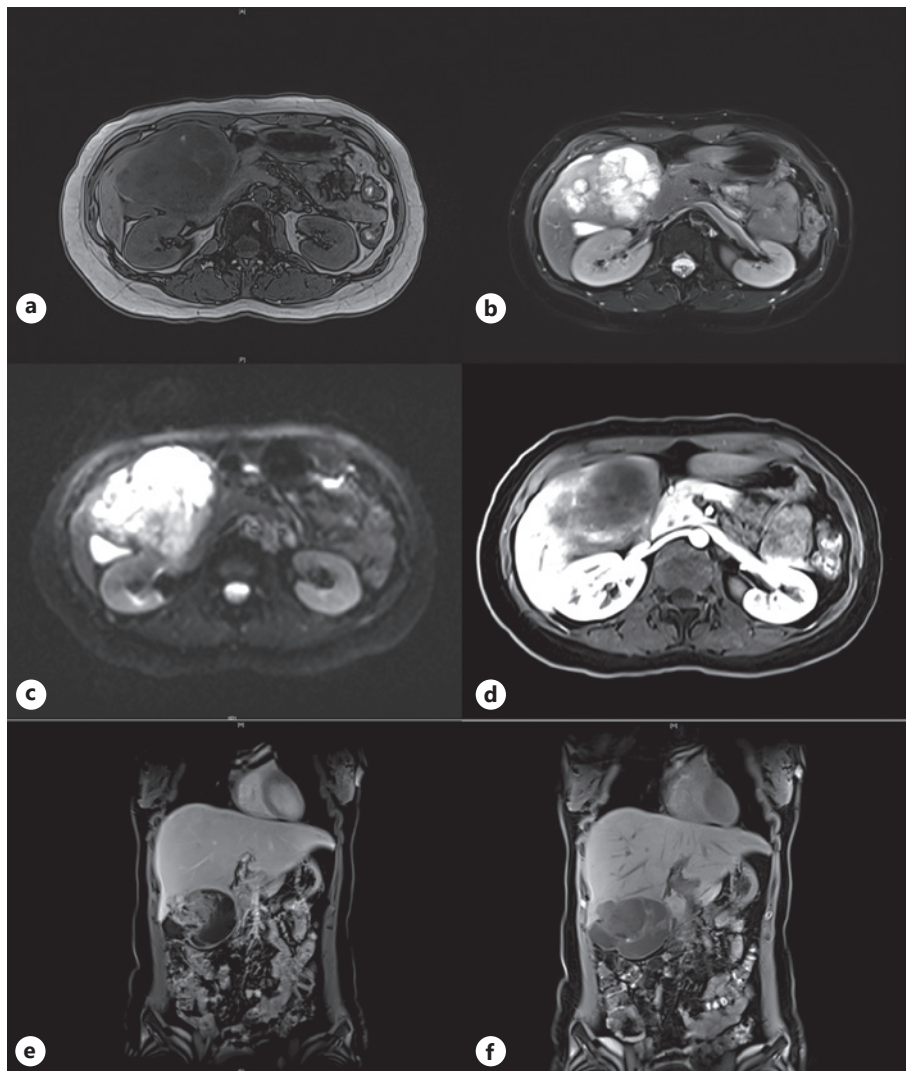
MR imaging of BAF. MR imaging features of BAF in the liver of the patient. a T1-weighted image. b T2-weighted image. c Diffusion-weighted imaging (DWI). d Dynamic contrast-enhanced MR imaging. e, f Coronal plane images. A lobular mass (98 mm × 81 mm × 71 mm) could be seen between the lower edge of the left inner lobe of the liver and the descending segment of the duodenum, which was cystic and partly solid with obvious uneven signal. T1WI showed low/equal/slightly high confounding signal (a). T2WI showed slightly higher/high confounding signal. Separation showed slightly lower signal (b). On DWI, the solid part showed limited dispersion (c). The enhanced scan shows progressive enhancement in the solid component while no enhancement was seen in cystic part. No contrast agent uptake could be seen in the hepatobiliary stage. The uptake in the left inner hepatic lobe was reduced and there was no clear boundary between the lesion and the left inner lobe in the hepatobiliary stage (f, white arrow).
